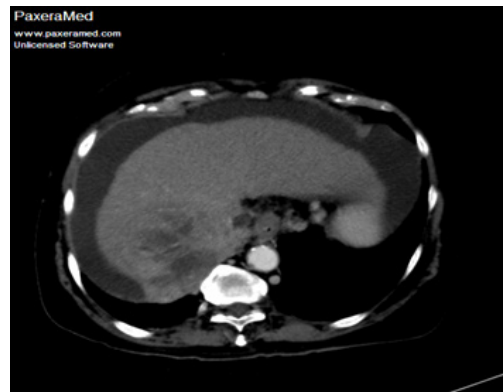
A 85-year-old male patient. Axial abdominal contrast-enhanced CT shows HCC with liver cirrhosis
